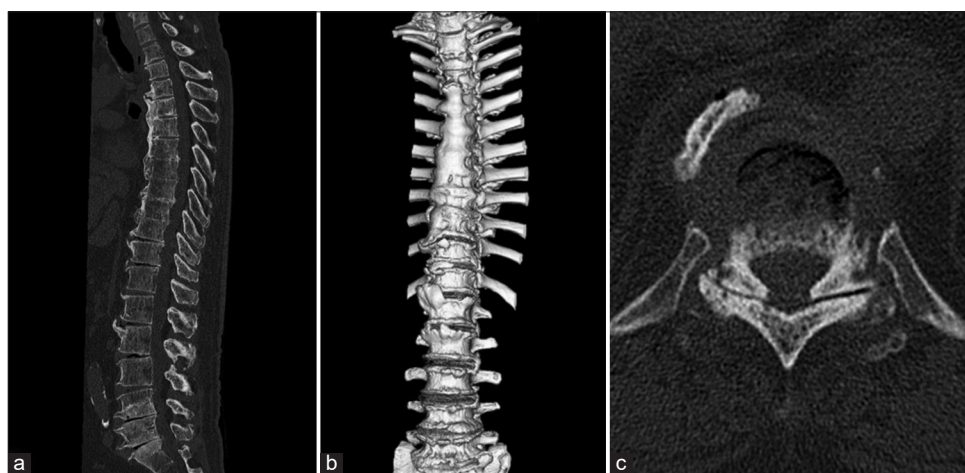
Computed tomography scan images of the whole spine. (a) Sagittal view shows horizontally oriented ossification of anterior longitudinal ligament in thoracic spine and gas-containing disc at multiple levels. (b) 3D reconstruction image reveals bridging of vertebral bodies from Th4 to Th10. (c) Axial image shows gas within Th10/11 facet joint.
